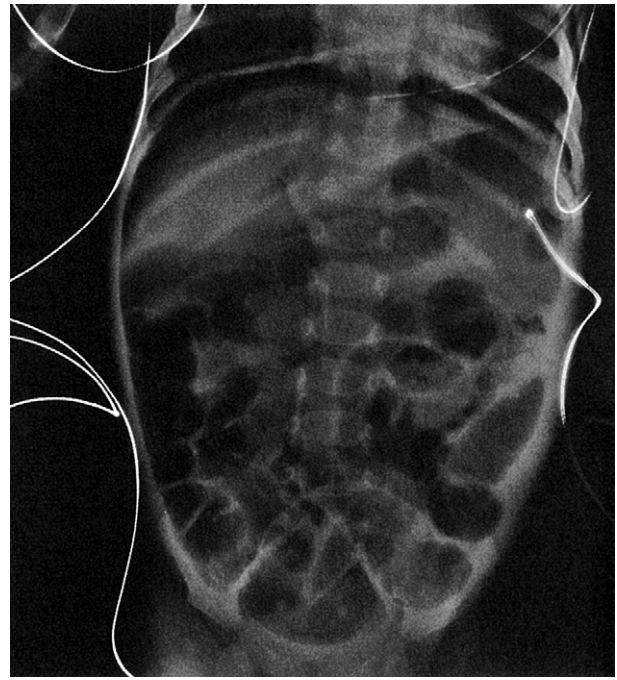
Abdominal radiograph in an infant with spontaneous gastric perforation shows free air in the peritoneal cavity.
